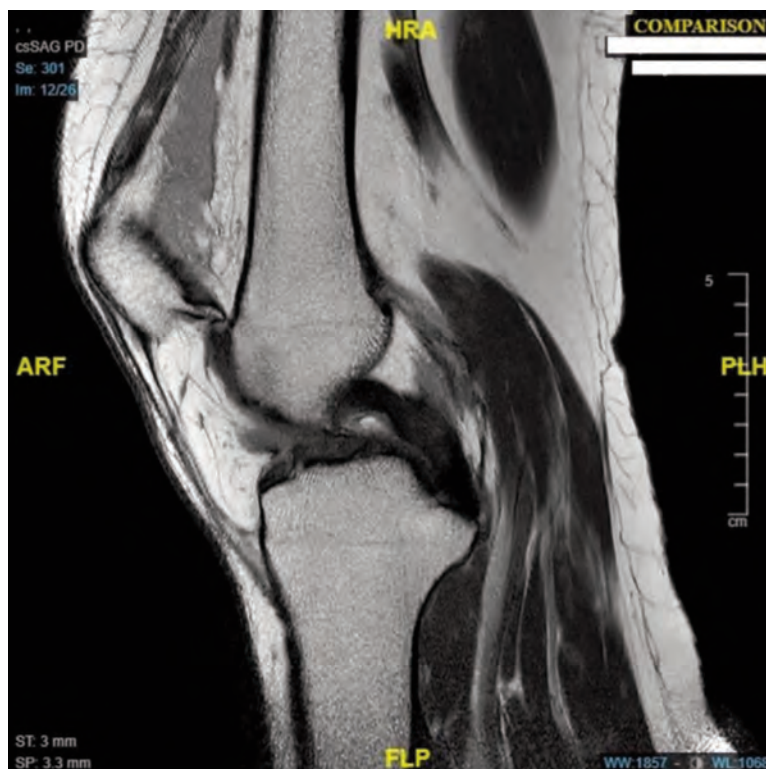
T1-weighted sagittal MRI of the left knee showing inferior osteophyte of the patella perched onto the trochlear, resulting in a superior dislocation of the patella.
